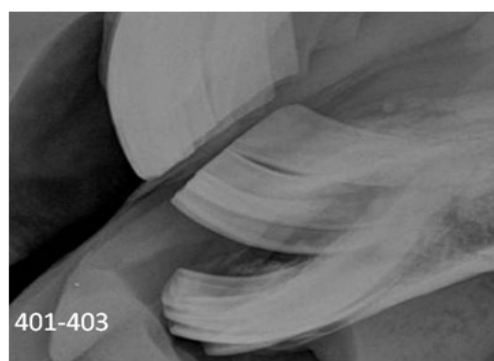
This radiograph was taken Jan.10, 2009 showing the ventrally displaced mandibular fragment which includes incisor teeth 401 – 403
